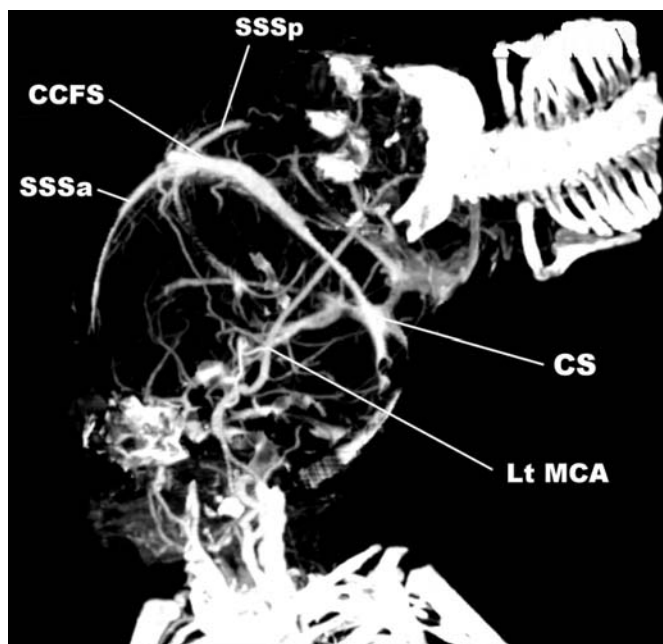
CT angiogram of the craniopagus parasitic twins. The left middle cerebral artery (Lt MCA) of the autosite is enlarged and anastomoses with the right middle cerebral artery of the parasite. It carries blood from the autosite to the circle of Willis of the parasite and then to the rest of its body. The anterior third of the superior sagittal sinus of the parasite (SSSp) joins the anterior third of the superior sagittal sinus of the autosite (SSSa) to form the circumferential sinus (CCFS). The circumferential sinus ends in the confluence of sinuses (CS).
